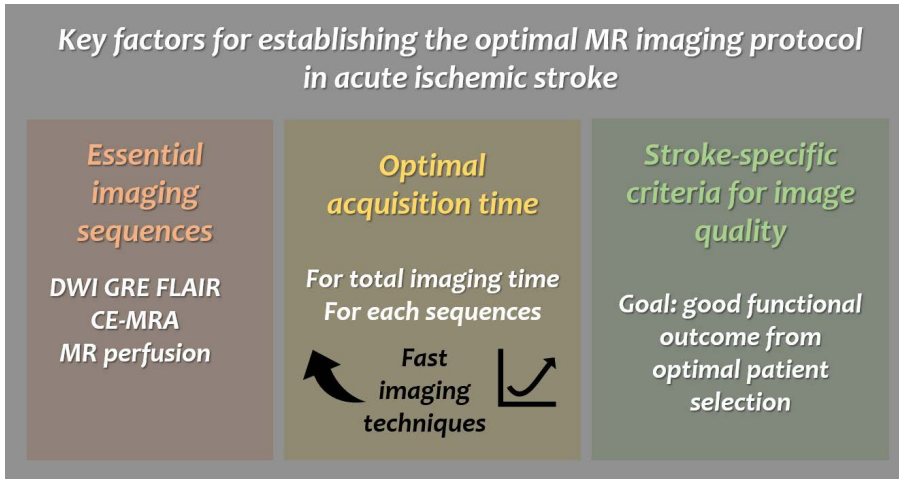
Key factors for establishing the optimal MR imaging protocol for acute ischemic stroke. CE-MRA = contrast-enhanced magnetic resonance angiography; DWI = diffusion-weighted imaging; FLAIR = fluid-attenuated inversion recovery; GRE = gradient-echo; MR = magnetic resonance
